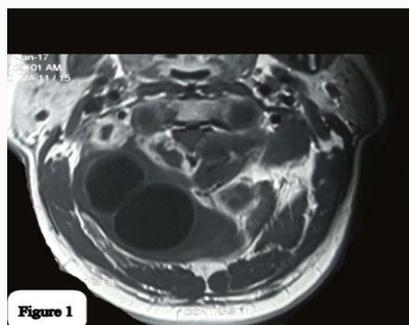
MRI (T1 axial)-Multilocular cystic lesion in right paravertebral region at C1-C2 level extending to posterior triangle, exhibiting low signal on T1 weighted.
